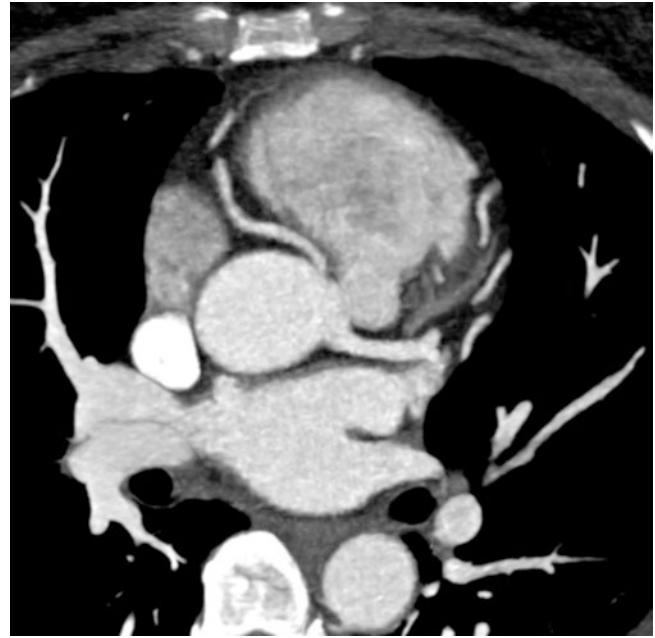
Myocardial bridging. MPR image from a coronary CT study performed on an ED patient with chest pain demonstrates long intramyocardial course of the mid-LAD, without narrowing of the bridged segment
